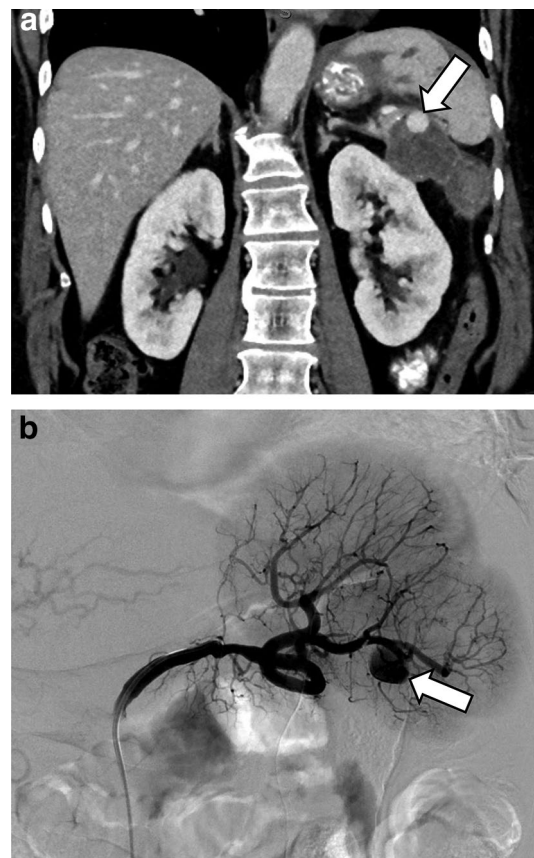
Vascular complications after partial resection of pancreas for chronic pancreatitis. Coronal contrast-enhanced CT image (a) and angiographic image from splenic artery injection (b) in a patient with distal pancreatectomy, complicated by pancreatic leak and secondary splenic artery pseudoaneurysm (arrows in a and b)
